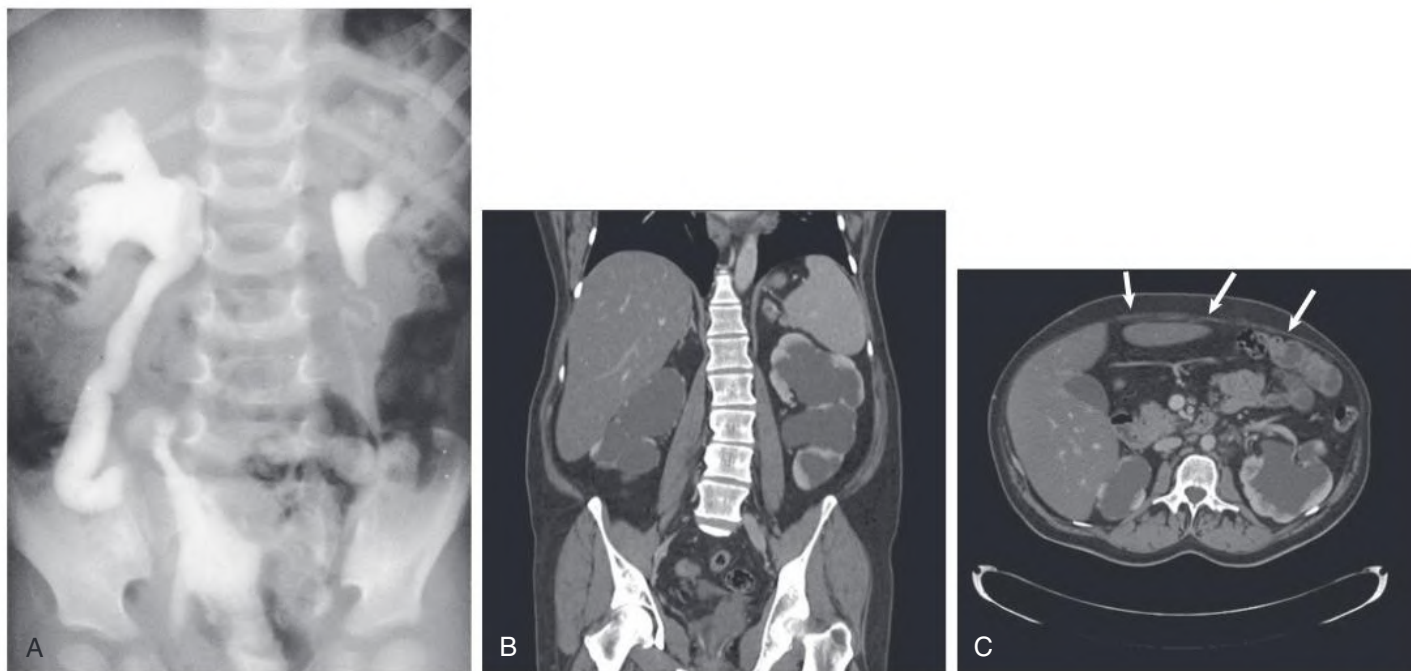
Prune-Belly Syndrome. (A) Typical intravenous urogram appearance of a patient with prune-belly syndrome and good kidney function. Often, the ureters are extremely dilated and tortuous. (B) Computed tomography urogram showing gross bilateral hydronephrosis. (C) Absence of anterior abdominal wall musculature (arrows).
